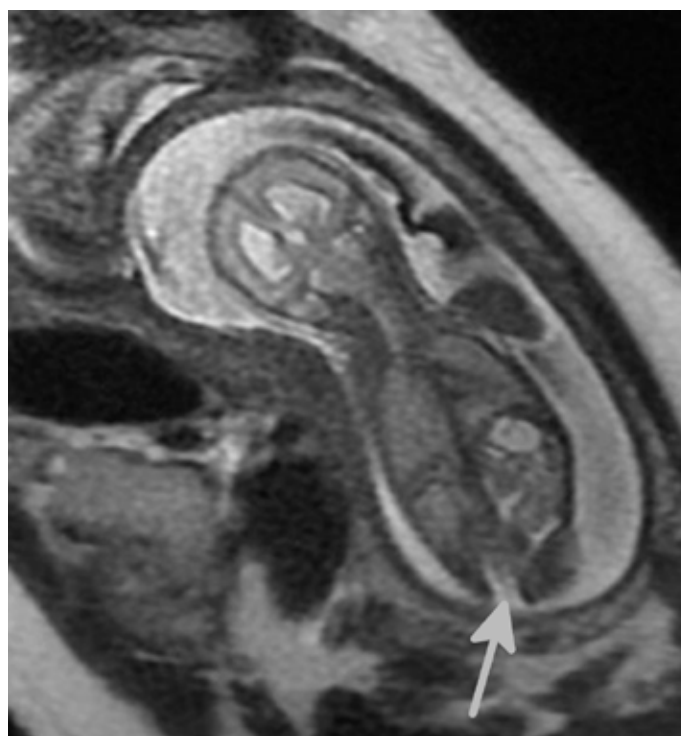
A 22/40 gestation fetus, with possible spinal dysraphism found on antenatal ultrasound. MRI demonstrates posterior spinal defect at the lower lumbar level (arrow), and enlarged lateral ventricles.
